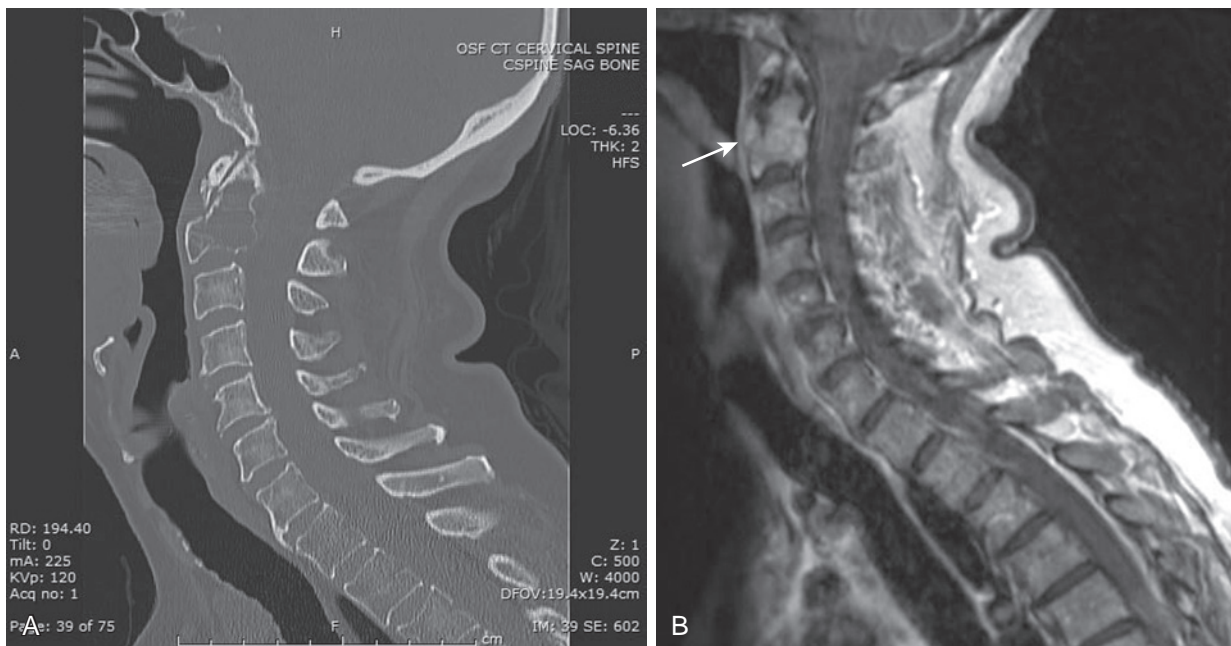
(A) A 76-year-old woman presented with neck pain after falling down stairs. Cervical spine computed tomography scan shows a lytic expansile lesion involving the C2 vertebral body with associated pathologic fracture. (B) Magnetic resonance imaging (MRI) shows a T2 high-signal enhancing soft tissue mass (*arrow*) involving C2 vertebral body extending into bilateral pedicles, confined by the posterior longitudinal ligament without extension into epidural space. (C) Bone scan shows increased radiotracer uptake in the C1-C2 vertebral body region, correlating with the expansile enhancing lesion on MRI.
